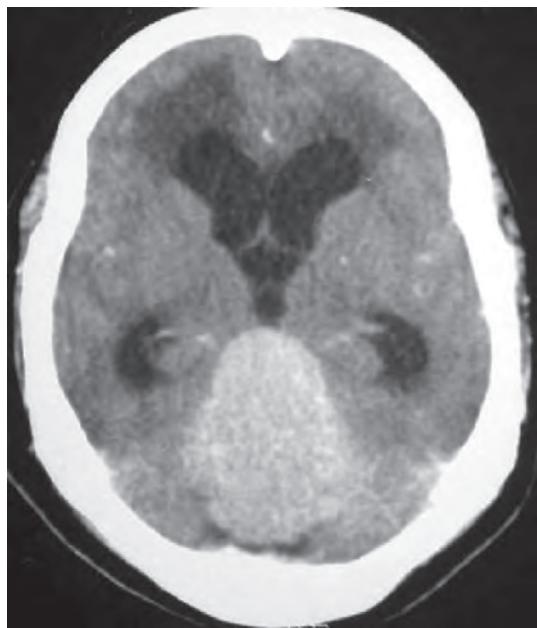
Contrast enhanced axial CT scan showing a falctentorial meningioma with predominantly infratentorial component with associated hydrocephalus. The lesion was extending to the posterior third ventricular region obstructing CSF pathway
